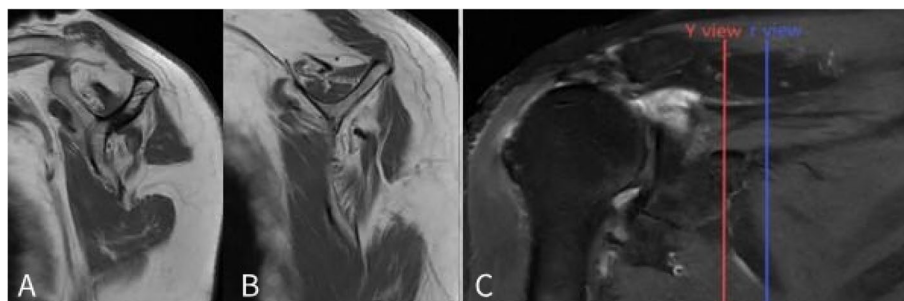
MR images of patients with stage 3 tendon retraction according to the Patte classification. A T1-weighted MR image of the Y view; (B) T1-weighted MR image of the r view; (C) T2-weighted coronal view of the shoulder MRI with the left vertical line showing the position of the Y view in the scapula and the right vertical line showing the position of the r view
